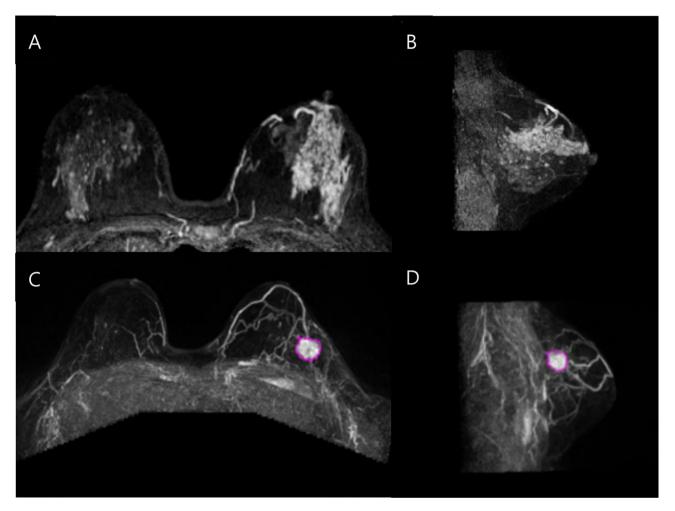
Representative magnetic resonance imaging (MRI) images of breast cancer with and without nonmass Lesions (NMLs). (A,B) Preoperative MRI images of breast cancer patients with NMLs showing characteristic enhancement patterns. (C,D) Preoperative MRI images of breast cancer patients without NMLs demonstrating absence of enhancement indicative of NMLs.
